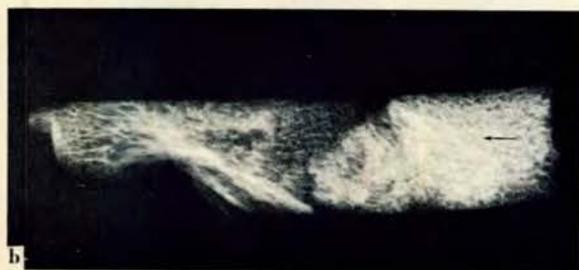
(a) A-P view of R hip of 51-year-old Caucasian male with idiopathic osteonecrosis, showing location of Turkel biopsy drilling trocar in subchondral bone of femoral head. (b) High-resolution roentgenogram of osseous cylinder (1 x 5 cm) obtained from femoral head by biopsy drilling. Arrow points to sclerotic (and necrotic) lesions.
